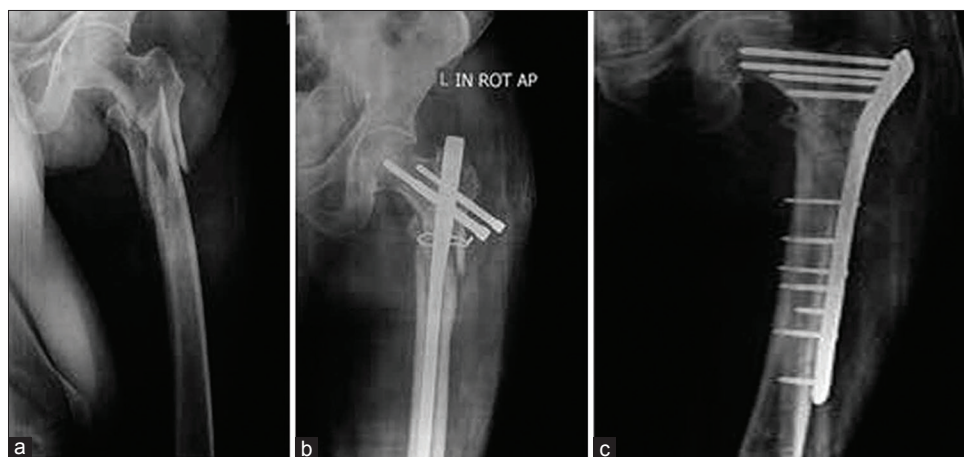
(a) X-ray left hip joint with thigh anteroposterior view showing comminuted subtrochanteric fracture femur (b) long proximal femoral nail with nonunion at 9 months after primary fixation. (c) The implant was removed and revision fixation was performed in the compression mode with reverse distal femoral locking compression plate. The radiographs show union at the 4-month followup
